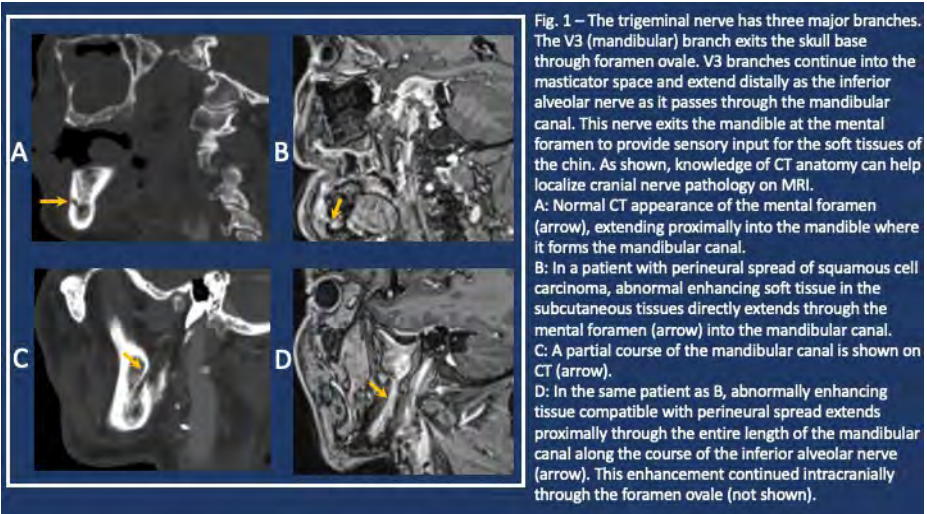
The trigeminal nerve has three major branches. The V3 (mandibular) branch exits the skull base through foramen ovale. V3 branches continue into the masticator space and extend distally as the inferior alveolar nerve as it passes through the mandibular canal. This nerve exits the mandible at the mental foramen to provide sensory input for the soft tissues of the chin. As shown, knowledge of CT anatomy can help localize cranial nerve pathology on MRI.
